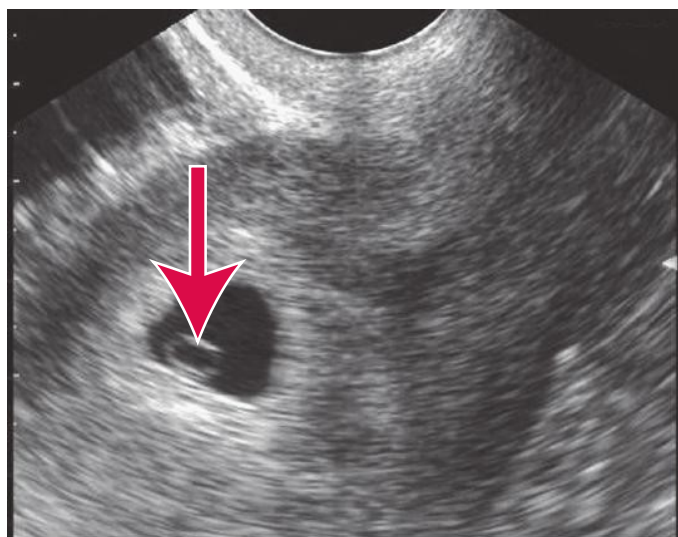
Yolk sac (arrow) within an intrauterine gestational sac. Normal early pregnancy. Transvaginal image. [Reproduced with permission from Ma OJ, Mateer JR, Reardon RF, Joing SA: *Ma & Mateer's Emergency Ultrasound*, 3rd ed. © 2014, McGraw-Hill Inc., New York.]
